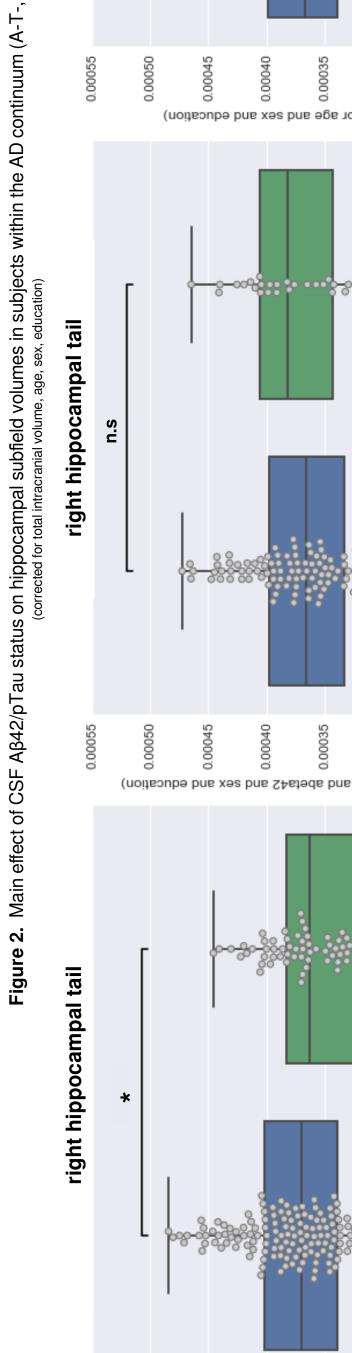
Main effect of CSF The two plots on the left show subjects withi Acknowledgements: The research leading to these results has received funding from international anonymous charity foundation through the TriBEKa Imaging Platform project the CSF analysis of ALFA+ participants. References: [1] Dubois, B. (2016) Preclinical Alzheimer's disease: Definition, natural h Neuroimaging in Alzheimer's Disease: Early Diagnosis, Physiopathological Mechanisms, an project: A research platform to identify early pathophysiological features of Alzheimer's di hippocampal formation using ex vivo, ultra-high resolution MRI: Application to adaptive segm
